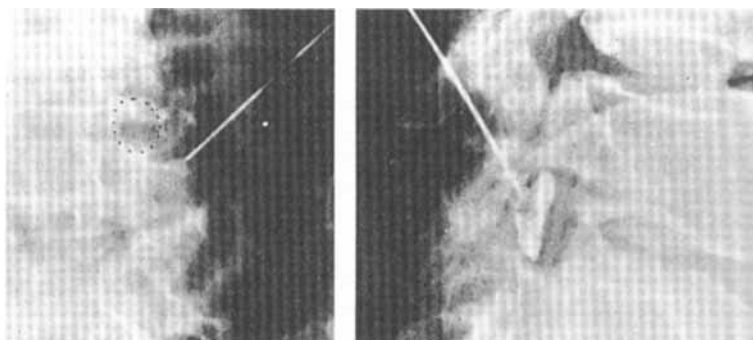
A-P and lateral radiographs of a L5 nerve root sheath infiltration. Note that the location of the needle tip is just outside the foramen intervertebrale. The radiographic image and the clinical observations confirmed a correct technique.
